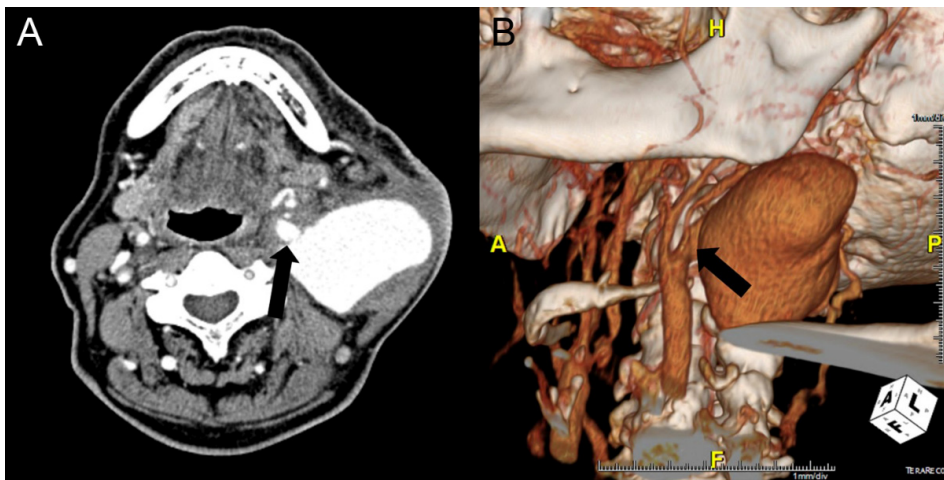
(A) Computed tomography scan of the neck showed a 6 cm x 4 cm sized pseudoaneurysm in the left internal carotid artery. (B) Three-dimensional reconstruction of the CT scan demonstrated leakage of contrast media from the internal carotid artery (arrow). On both images, external and internal carotid arteries were located in front of a fistula tract (arrow)
